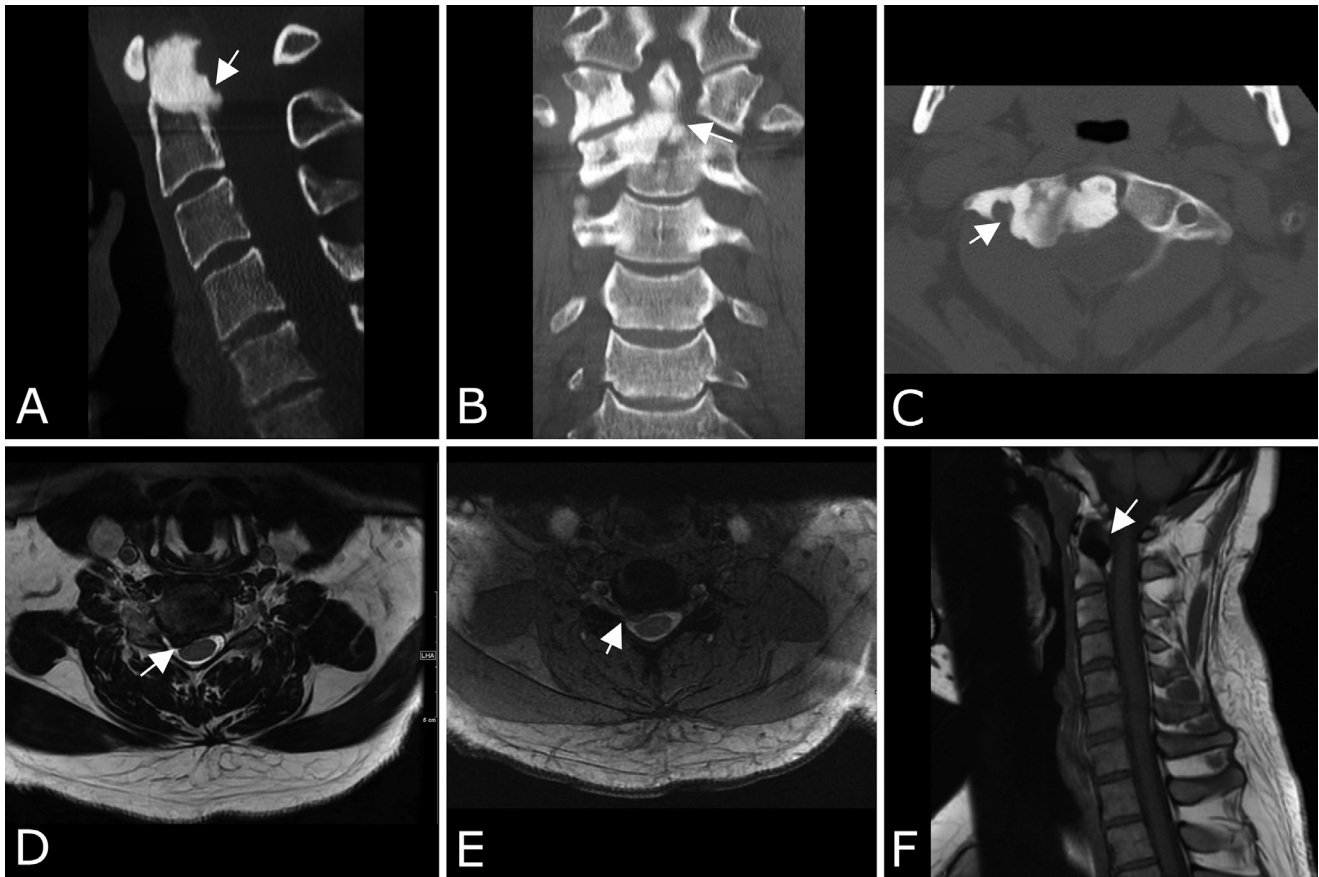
Computed tomography of the cervical spine obtained for initial evaluation of progressive neck pain with radiculopathy following a car accident. Sagittal (A), coronal (B), and axial (C) noncontrast CT images through the cervical spine demonstrate sclerotic lesions at C1 and C2 reminiscent of “dripping candle wax,” the characteristic finding in melorheostosis. The lesions are predominantly right-sided, and the sclerotomal unilaterality supports the diagnosis of melorheostosis. Magnetic resonance imaging of the cervical spine was subsequently obtained due to progression cervicalgia and right-sided cervical radiculopathy. Axial T2 SPACE (D) and axial T2-weighted MEDIC (E) images demonstrate a focal disk extrusion eccentric to the right at C5-C6 that impinges upon the right C6 nerve rootlets and indents the right ventral surface of the spinal cord. Sagittal T1-weighted imaging (F) shows the expected T1 hypointense signal of a sclerotic bone lesion in the odontoid process, and further demonstrates the hyperostotic expansion initially shown on CT.
